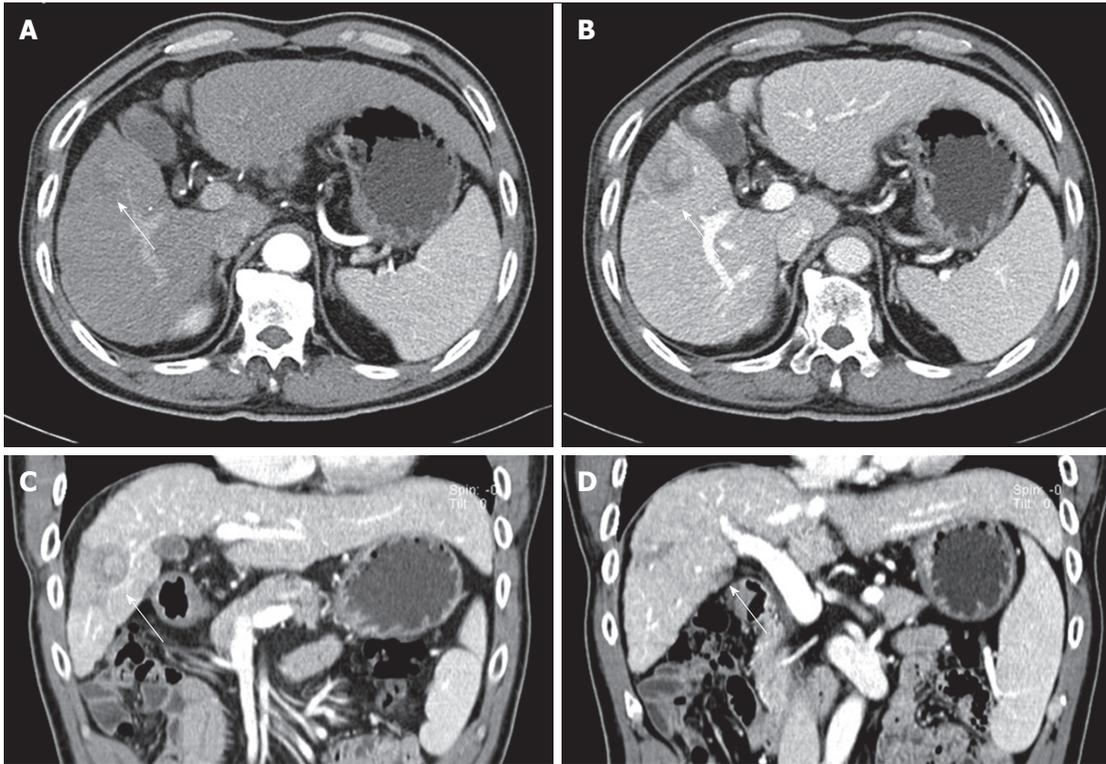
Computed tomography scan results. A: An ill-defined, low-attenuated lesion was observed in the right anterior segment on late arterial phase image (arrow); B: The lesion was more clearly seen as a low-attenuated, poorly enhanced lesion in the portal phase. Central high-attenuated portion was observed; C: Coronal reformat image in the portal phase, showing the low-attenuated lesion pushing against the segmental portal vein, resulting in its narrowing (arrow); D: Another coronal reformat image in the portal phase, showing a low-attenuated, poorly enhanced lesion in segment V (arrowhead).
